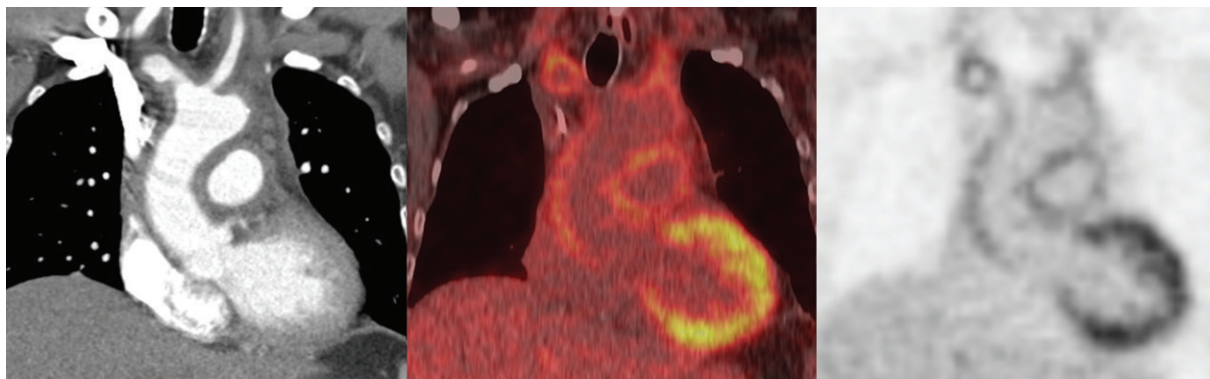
Lenalidomide-associated large-vessel vasculitis in a 47-year-old man with multiple myeloma. The patient presented with progressive subacute chest pain, shortness of breath, and fever. Evaluation with contrast-enhanced coronal CT (left image), fused FDG PET/CT (middle image), and PET (right image) was performed. Contrast-enhanced CT and FDG PET/CT images show new diffuse wall thickening of the aorta, great vessels, and pulmonary artery, with circumferential hypermetabolic activity. Infectious and rheumatologic workup results were negative, and the patient's symptoms and imaging findings resolved following steroid treatment and discontinuation of the current multiple myeloma therapy regimen, with transition to an alternative treatment regimen.
